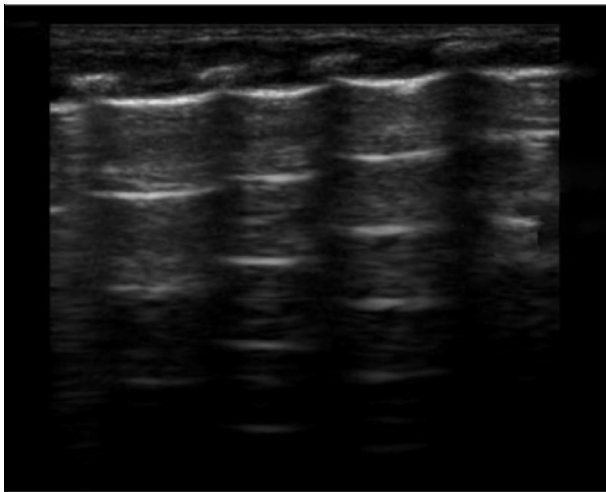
Normal ultrasonographic appearance of healthy neonatal lung.
